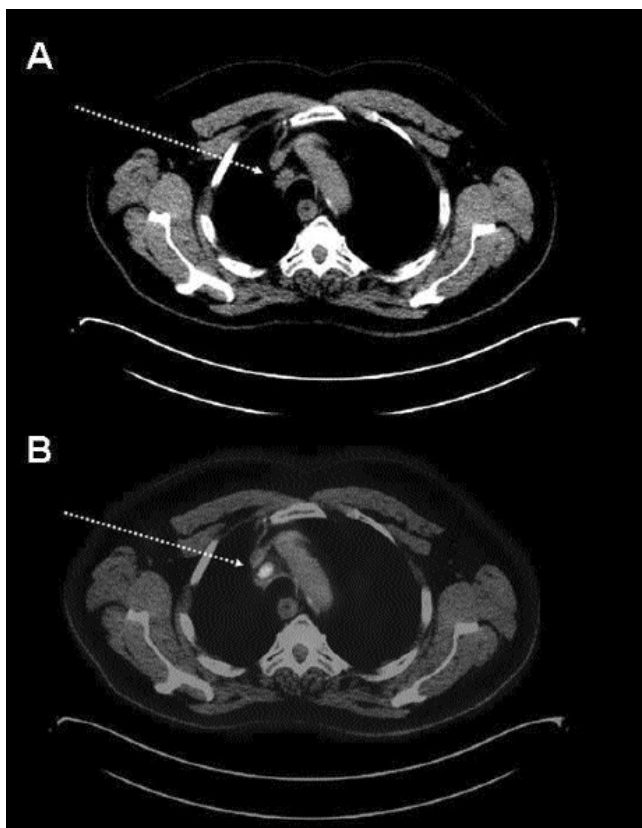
On the top (A): computed tomography scan of the mediastinum with an oval right paratracheal lymph node having 8mm diameter on short axis (dotted arrow); on the bottom (B) Positron emission tomography/computed tomography fusion scan showing pathological fluorodeoxyglucose uptake at this site (dotted arrow).
